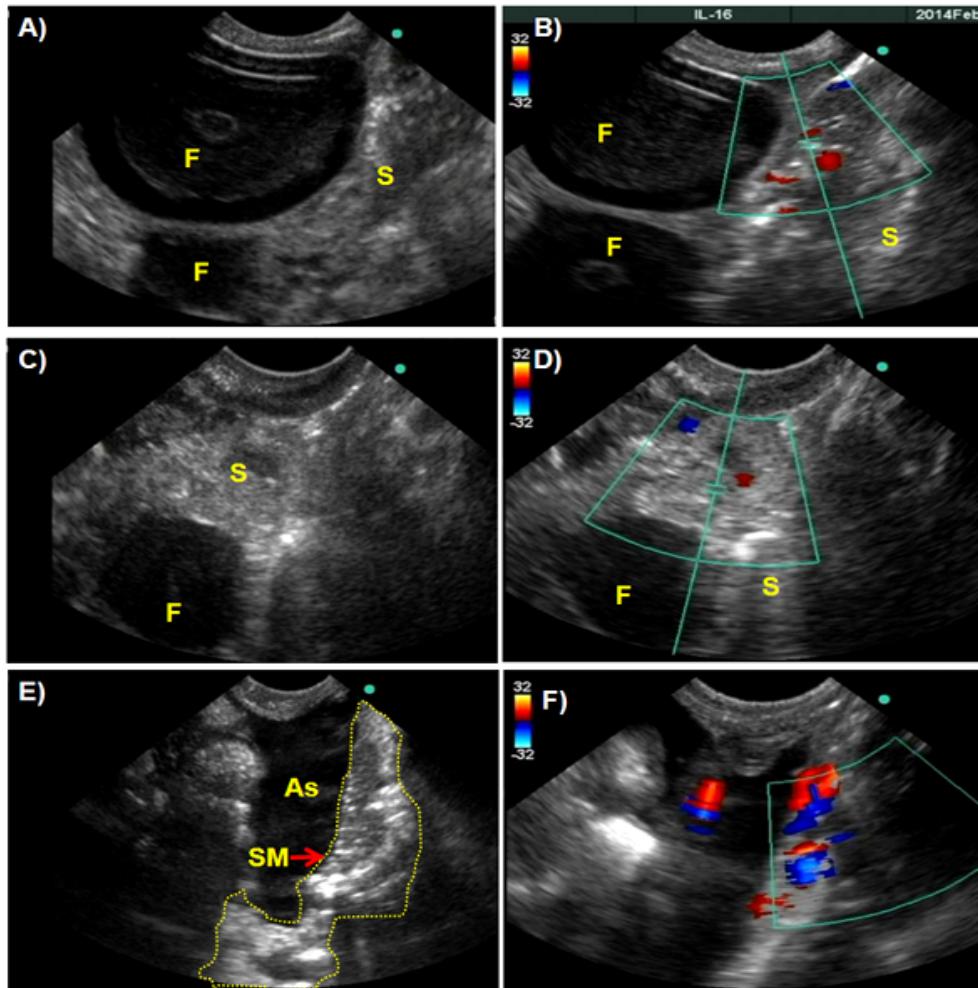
Changes in ovarian morphology leading to tumor development in hens detected by prospective IL-16-targeted molecular ultrasound imaging. A-B) Gray scale and Doppler sonogram of a hen ovary at 1st scan showing two developing preovulatory follicles (F) in the stroma (S). No abnormality was detected in gray scale ovarian morphology and in ovarian vasculature by Doppler ultrasound scan. C-D) At 2nd scan (30 weeks after) no remarkable change was observed in the same ovary by gray scale and Doppler sonography except the number of follicles. Compared with 1st scan, the number of developing follicle decreased as the hen ages. E-F) The hen presented in 1st and 2nd scan developed solid mass (SM) and detected by targeted imaging at 3rd scan. Compared with 1st and 2nd scan, more microvessels were detected during 3rd scan by Doppler imaging suggesting tumor associated changes in ovarian blood flow. As=Ascites.
